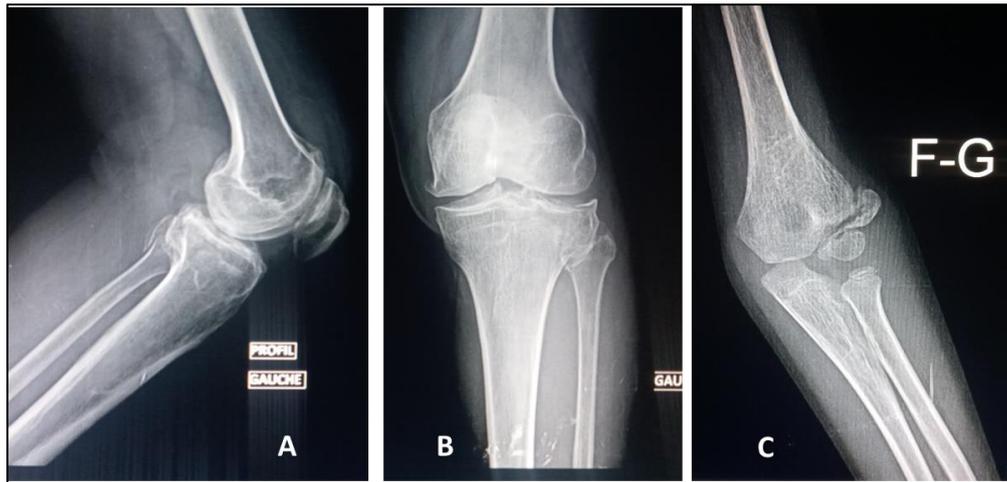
A, B and C): X-ray of the left knee in front and profile view (A and B) and of the left elbow in front view (C) shows a complex fracture with depression of the external tibial plateau and the upper extremity of the fibula (A and B) and an olecranon fracture associated with an inflammatory thickening of the peri-articular parts (C)
